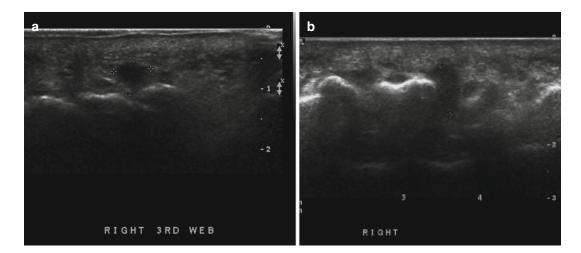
Typical Morton's neuroma in the intermetatarsal space as a hypoechoic mass (a, b) in ultrasonography
